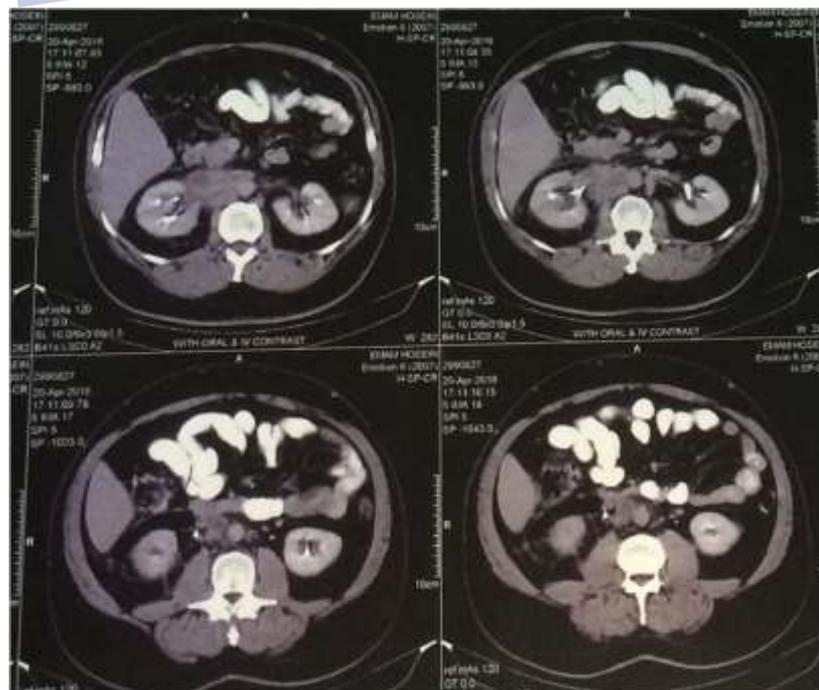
CT scan after chemotherapy also showed thrombosis inside the IVC, extending to both the common iliac veins
